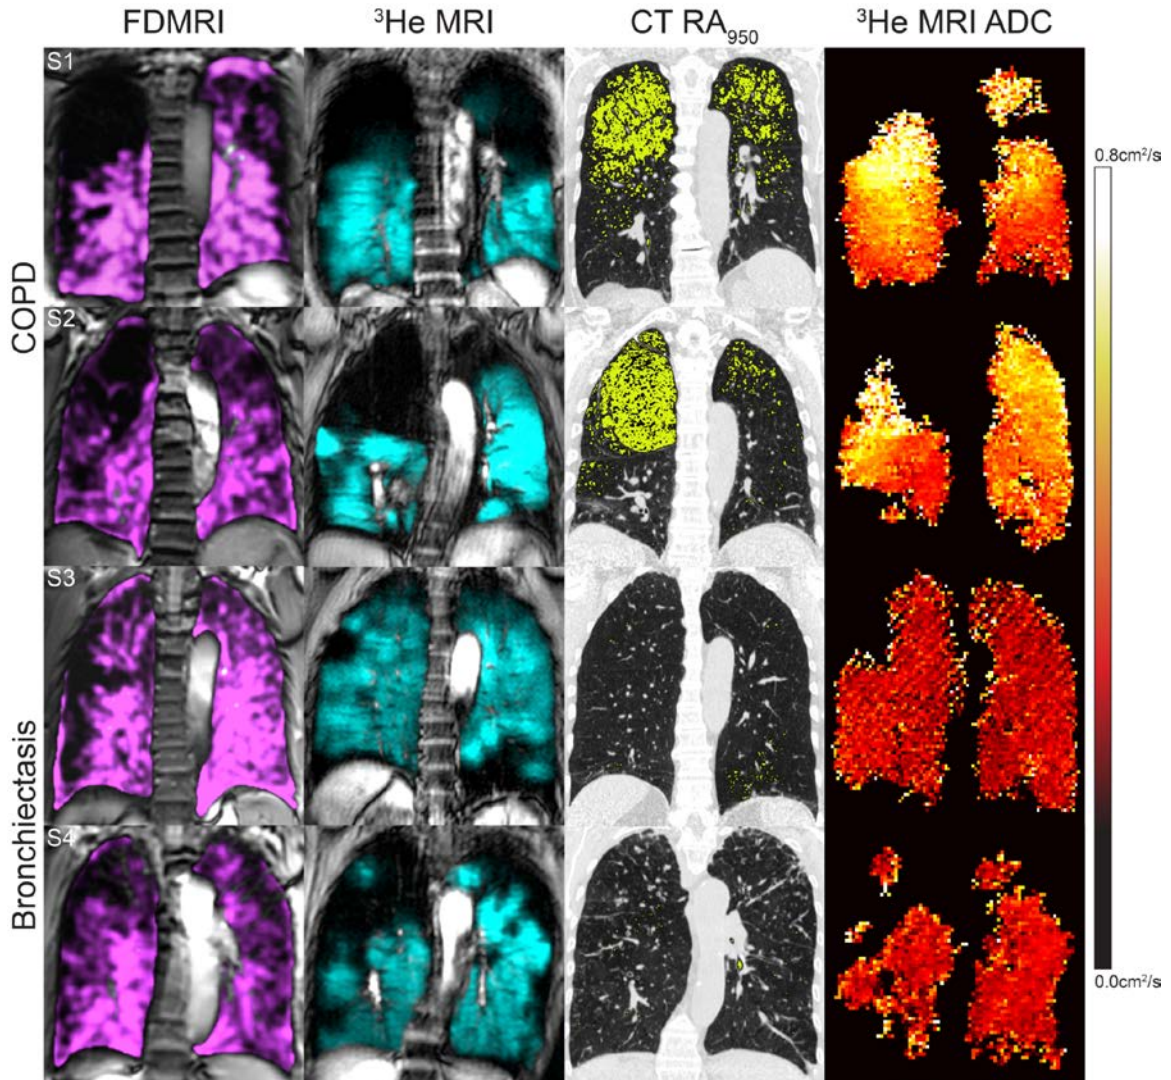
Ventilation and CT imaging for representative COPD and bronchiectasis subjects
